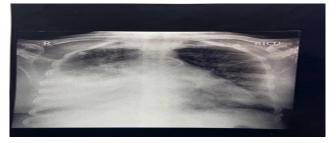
Chest radiograph showing homogeneous opacity in the right lower lung zone
